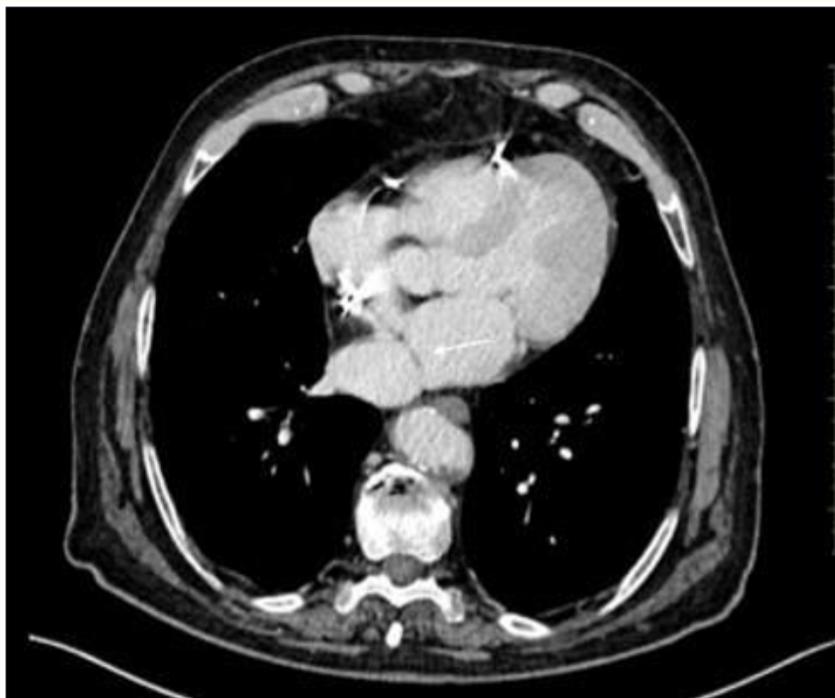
Case 2. Cardiac CT scan. Fibromuscular septum separating left atrium into two chamber.
